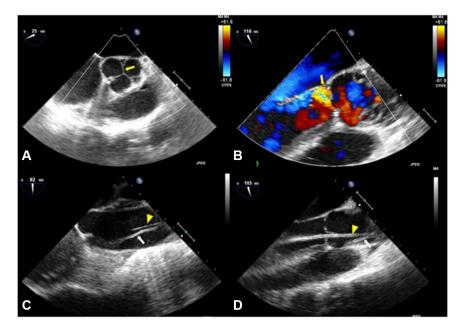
Intraoperative transesophageal echocardiographic guidance. Short-axis view showing good coaptation of the aortic valve leaflets (*yellow arrow*) (A) and Doppler ultrasound (B) demonstrating mild aortic insufficiency after crossing the valve with a stiff wire before device deployment. C and D, Long-axis views showing the realtionship of dissection flap to the wire (*yellow arrowhead* indicates dissection flap; *white arrow* shows the wire).
